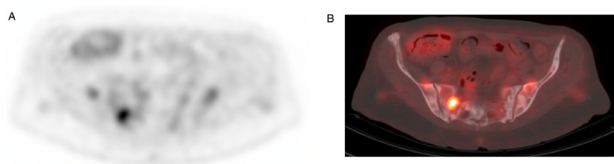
A 79-year-old female with infiltrating ductal carcinoma of the bilateral breasts treated with partial mastectomy and adjuvant chemotherapy. She developed osseous metastatic disease and was treated with denosumab. Axial PET and fused PET-CT images during treatment (A and B) showed areas of focal hypermetabolic activity within the right sacrum and left ileum. Axial CT image (C) demonstrated mixed lytic and sclerotic areas throughout the sacrum and pelvis. Findings were suggestive of mixed areas of both active and treated osseous metastatic disease.
